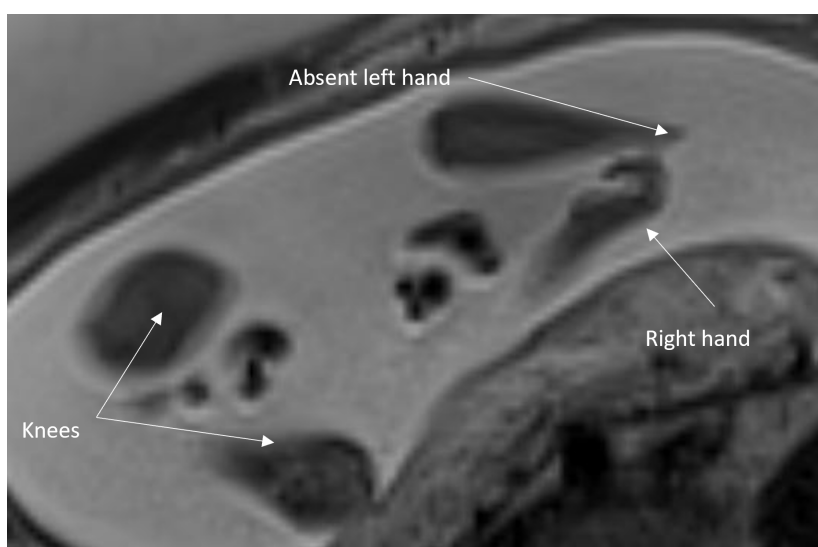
T2 HASTE Coronal MRI image of 22+1 week fetus with absent left hand
